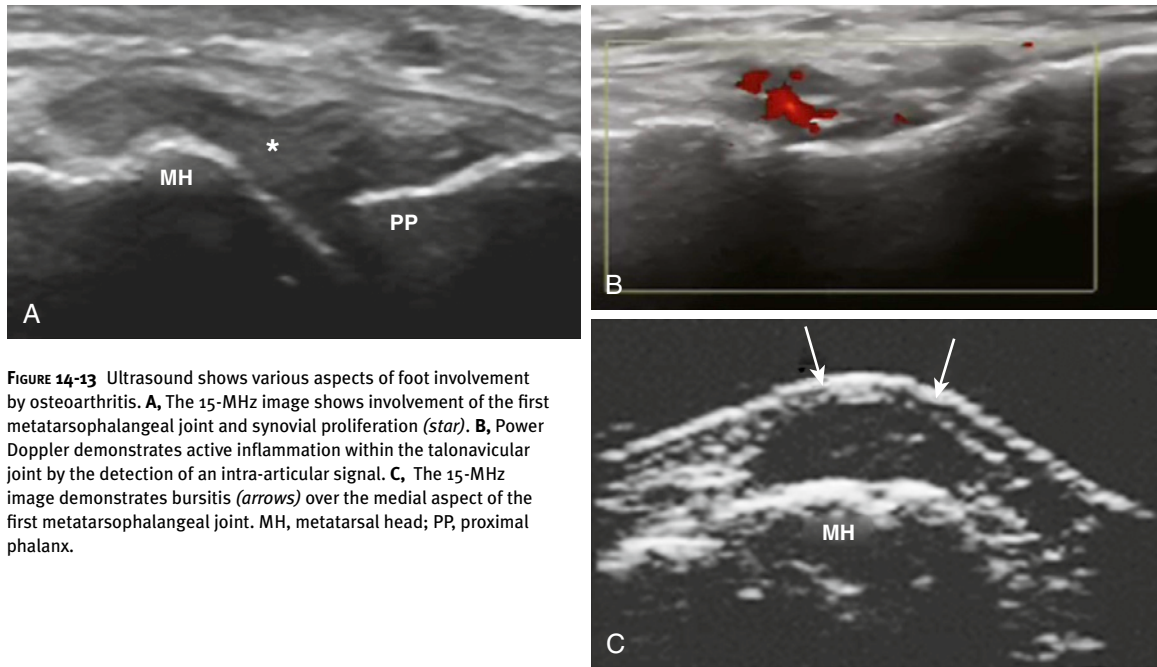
Ultrasound shows various aspects of foot involvement by osteoarthritis. A, The 15-MHz image shows involvement of the first metatarsophalangeal joint and synovial proliferation (*star*). B, Power Doppler demonstrates active inflammation within the talonavicular joint by the detection of an intra-articular signal. C, The 15-MHz image demonstrates bursitis (*arrows*) over the medial aspect of the first metatarsophalangeal joint. MH, metatarsal head; PP, proximal phalanx.
